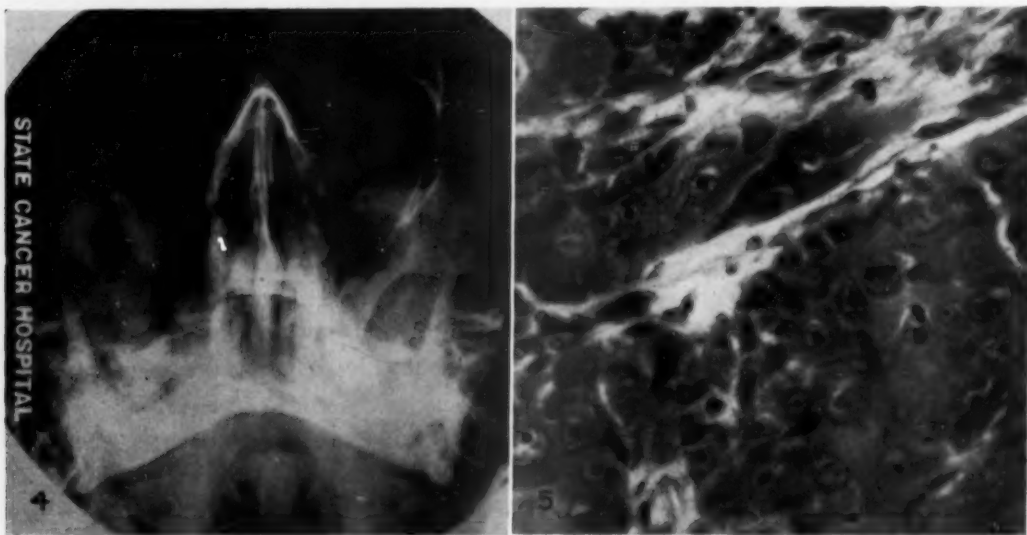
Case 2. Radiographic view of carcinoma of the right antrum.
